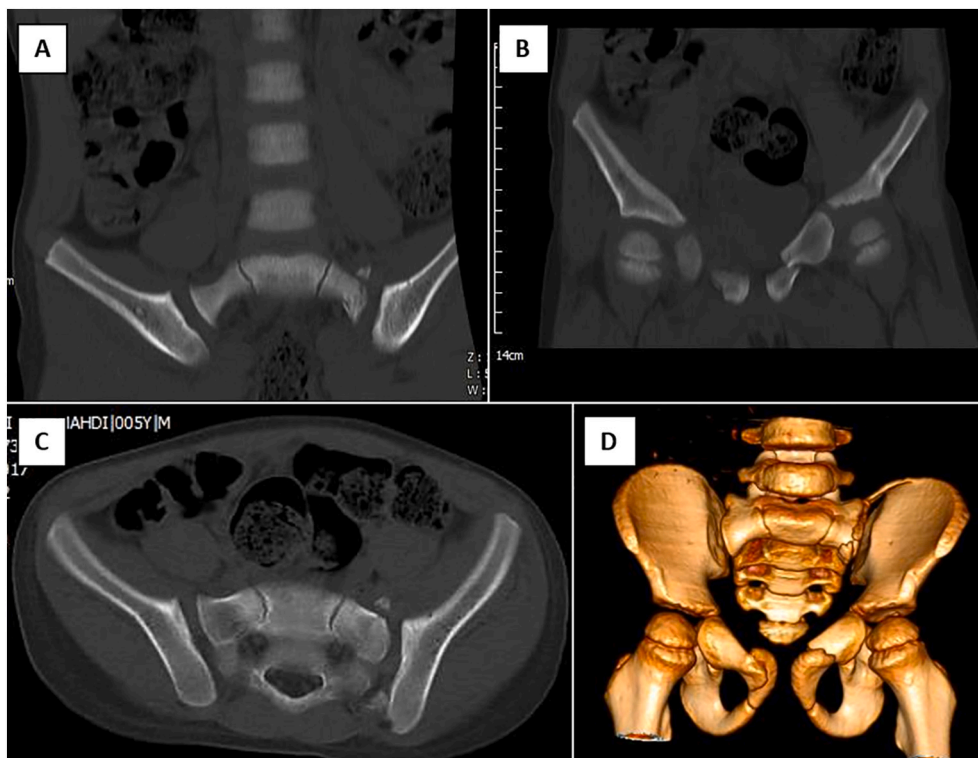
Pelvic radiography CT-scan. A, B. Axial plane. C. Coronal plane. D. 3D reconstruction.
